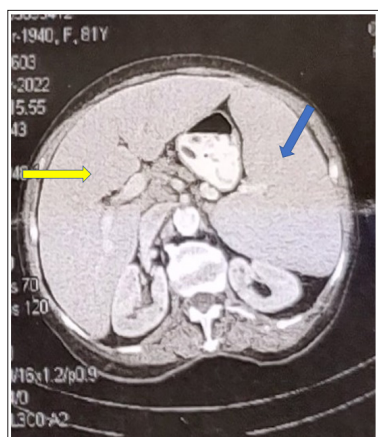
Sagittal CT view of mid abdominal cavity (moderate hepatomegaly – yellow arrow, massive splenomegaly – blue arrow)
